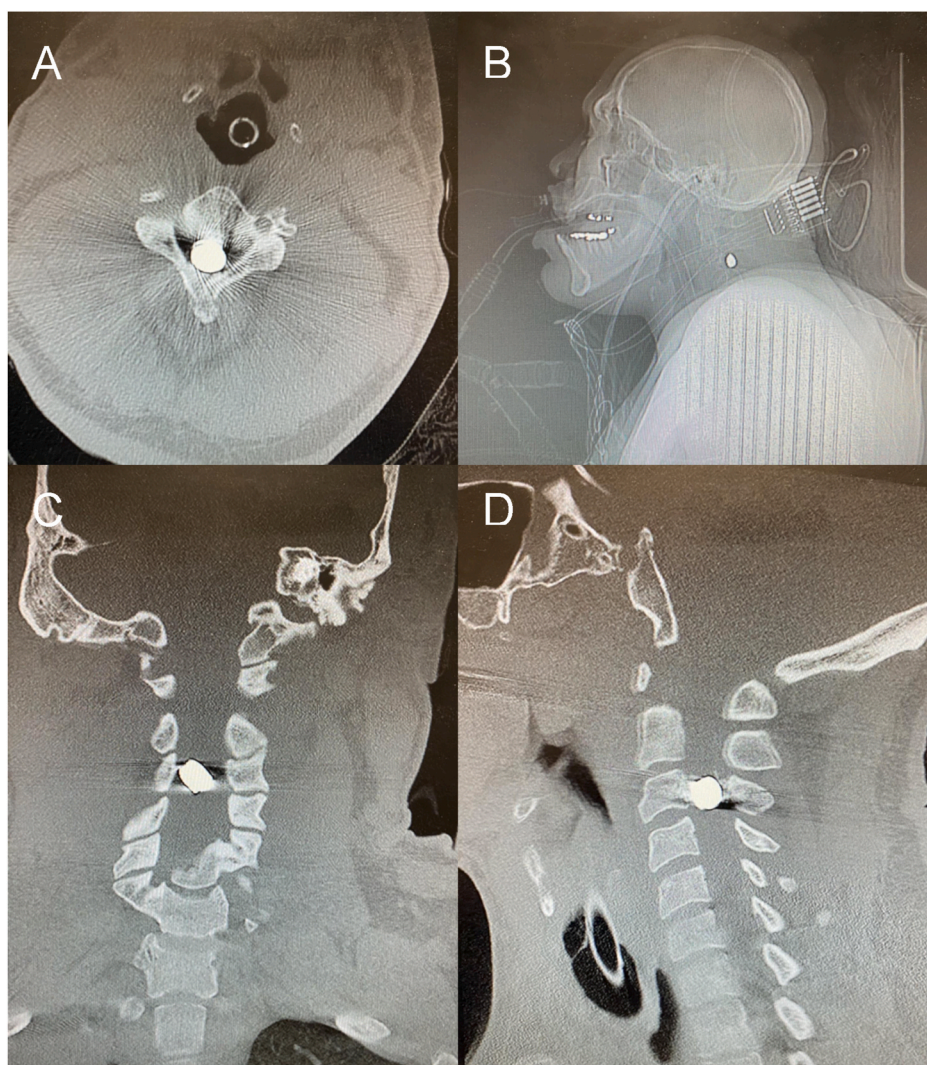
Retained bullet fragment is identified at the level of the third cervical vertebra. (A) Axial CT Cervical Spine without contrast. (B) Sagittal X-ray Head/Neck. (C) Coronal CT Cervical Spine without contrast. (D) Sagittal CT Cervical Spine without contrast.
